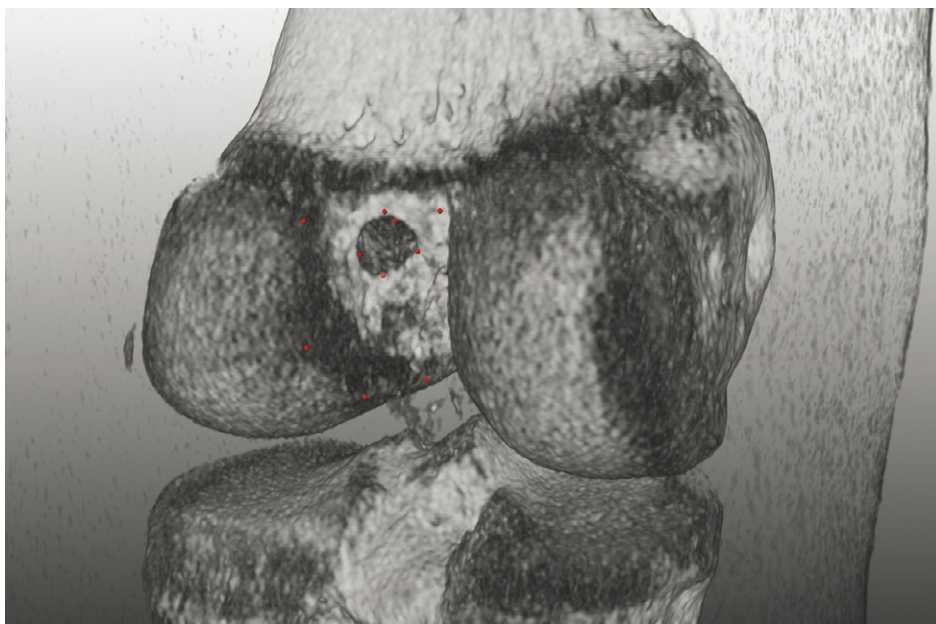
Posterolateral view of a 3-D CT of the ACL reconstructed left knee. The red dots show the 3-dimensional (MeVis) measurement points of the femoral tunnel opening and the intracondylar contour of the lateral femoral condyle.
